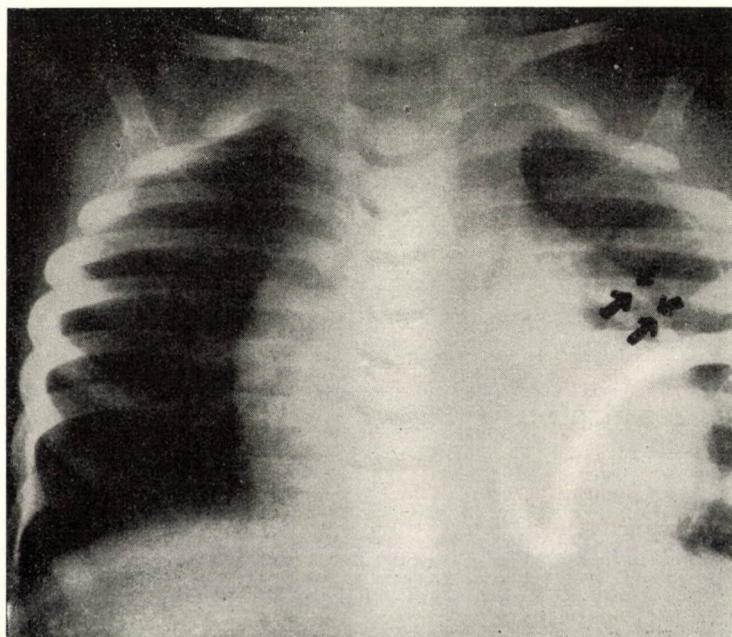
X-ray of the child in Fig. 1. Thickened pericardium with introduced tube is indicated by arrows
